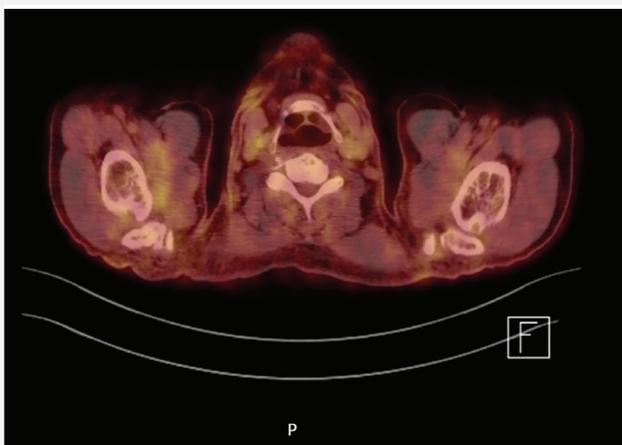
PET/CT findings: There is a reticulonodular density in the right axillary fossa showing increased FDG uptake (SUV_{max} : 4.9)
